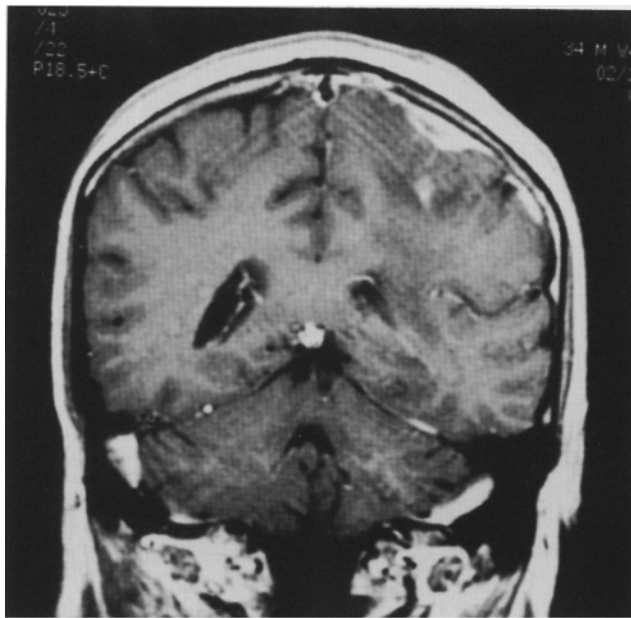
MRI images of the brain showing the tumor growth at the site of needle biopsy. A faint track leading to the primary tumor is visible (a).
